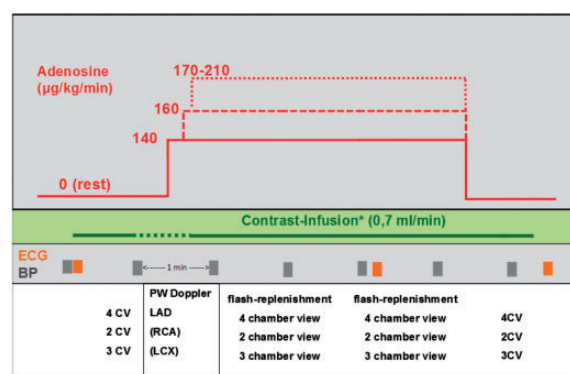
Protocol of adenosine SE; for abbreviations see Figure 10. Acquisition of flash-replenishment sequences are recommended for the assessment of myocardial perfusion. Coronary flow measurement in the LAD and if possible in other coronary arteries using PW Doppler are recommended at rest and 1 min after start of the adenosine infusion.
